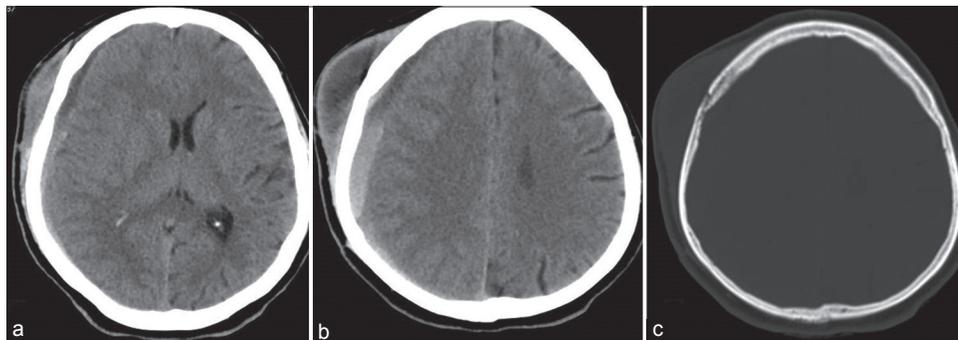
Plain computed tomography scan axial section of brain at the (a) and above the level of ventricles (b) showing large mixed density subgaleal, extradural, and subdural collections. Bone window (c) showing erosions and rarefaction of frontoparietal bones close to the coronal suture with diploic thinning suggestive of Osteomyelitis.
